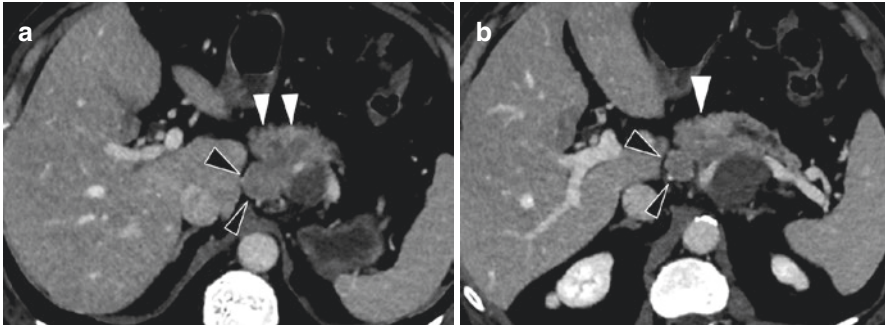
Nodal involvement. CT with contrast injection at the portal venous phase, axial views (a and b). Tissue mass in the pancreatic body and isthmus (white arrows), with upstream dilation of the pancreatic duct. Two enlarged peritumoral celiac nodes with abnormal features (rounded shape, smallest dimension longer than 10 mm)
